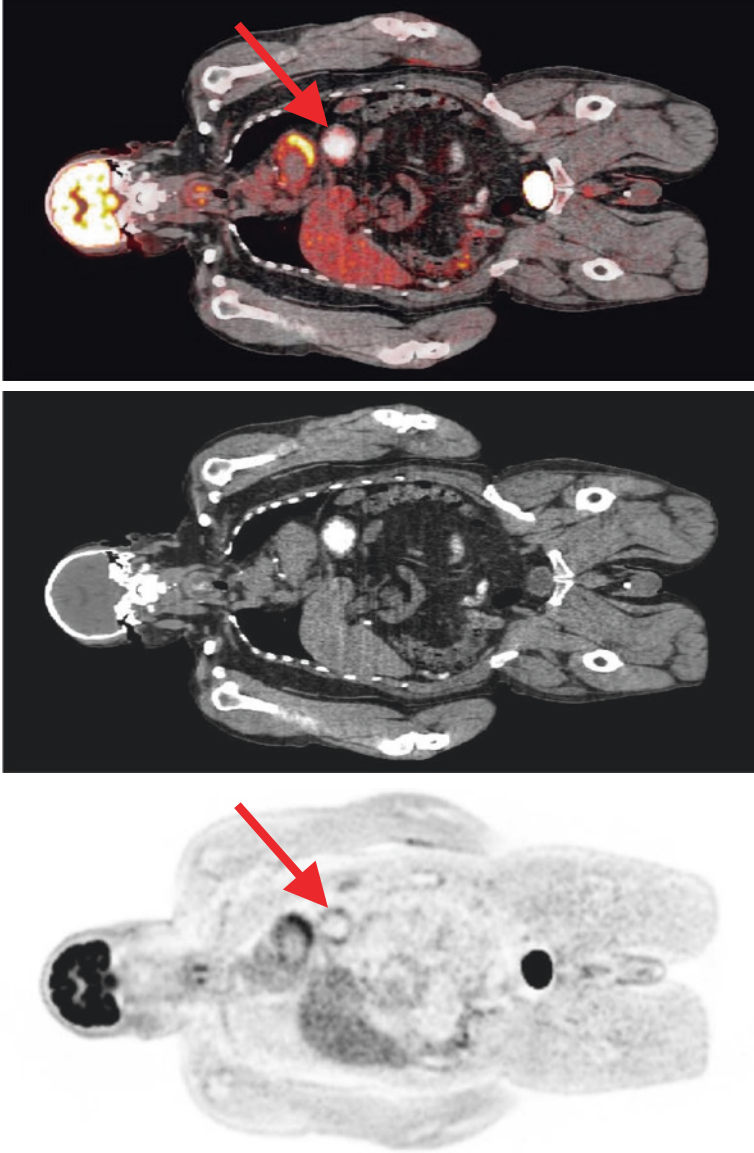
PET artifacts from the use of CT contrast agents in PET/CT: incorrect identification of regions with CT contrast can result in erroneous attenuation correction factors that can affect the PET image. Shown are PET (*left*), CT (*middle*), and fused PET/CT (*right*) images correlating area of CT contrast uptake with radioactivity overestimation (*red arrow*) resulting from IV contrast use. Images acquired courtesy of the Hospital of the University of Pennsylvania PET Center
